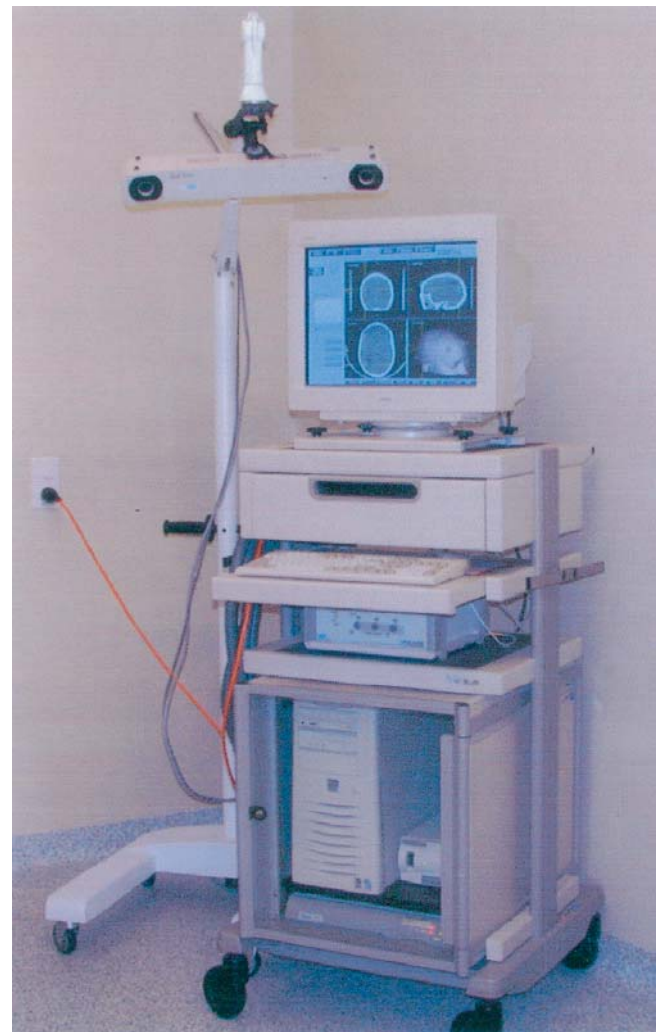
Computer-assisted surgery (CAS) system (Aesculap AG, Tuttlingen, Germany). On the left side is the infrared camera (Polaris, Northern Digital, Ontario, Canada) and on the right the workstation (Dell) with coronal, sagittal, and axial CT scans, and a three-dimensional view of the head with skin markers
